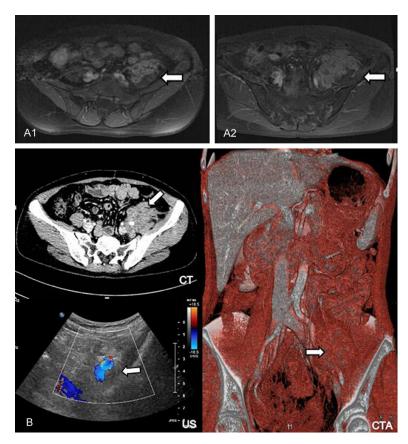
Imaging manifestations. A1. Axial post-contrast T1-weighted image shows a heterogeneous enhancement mass in the left psoas major. A2. Three months later the mass increases in size. B. The mass encases the left external iliac artery on axial CT, US and coronal CTA. White arrow shows the lesion.
